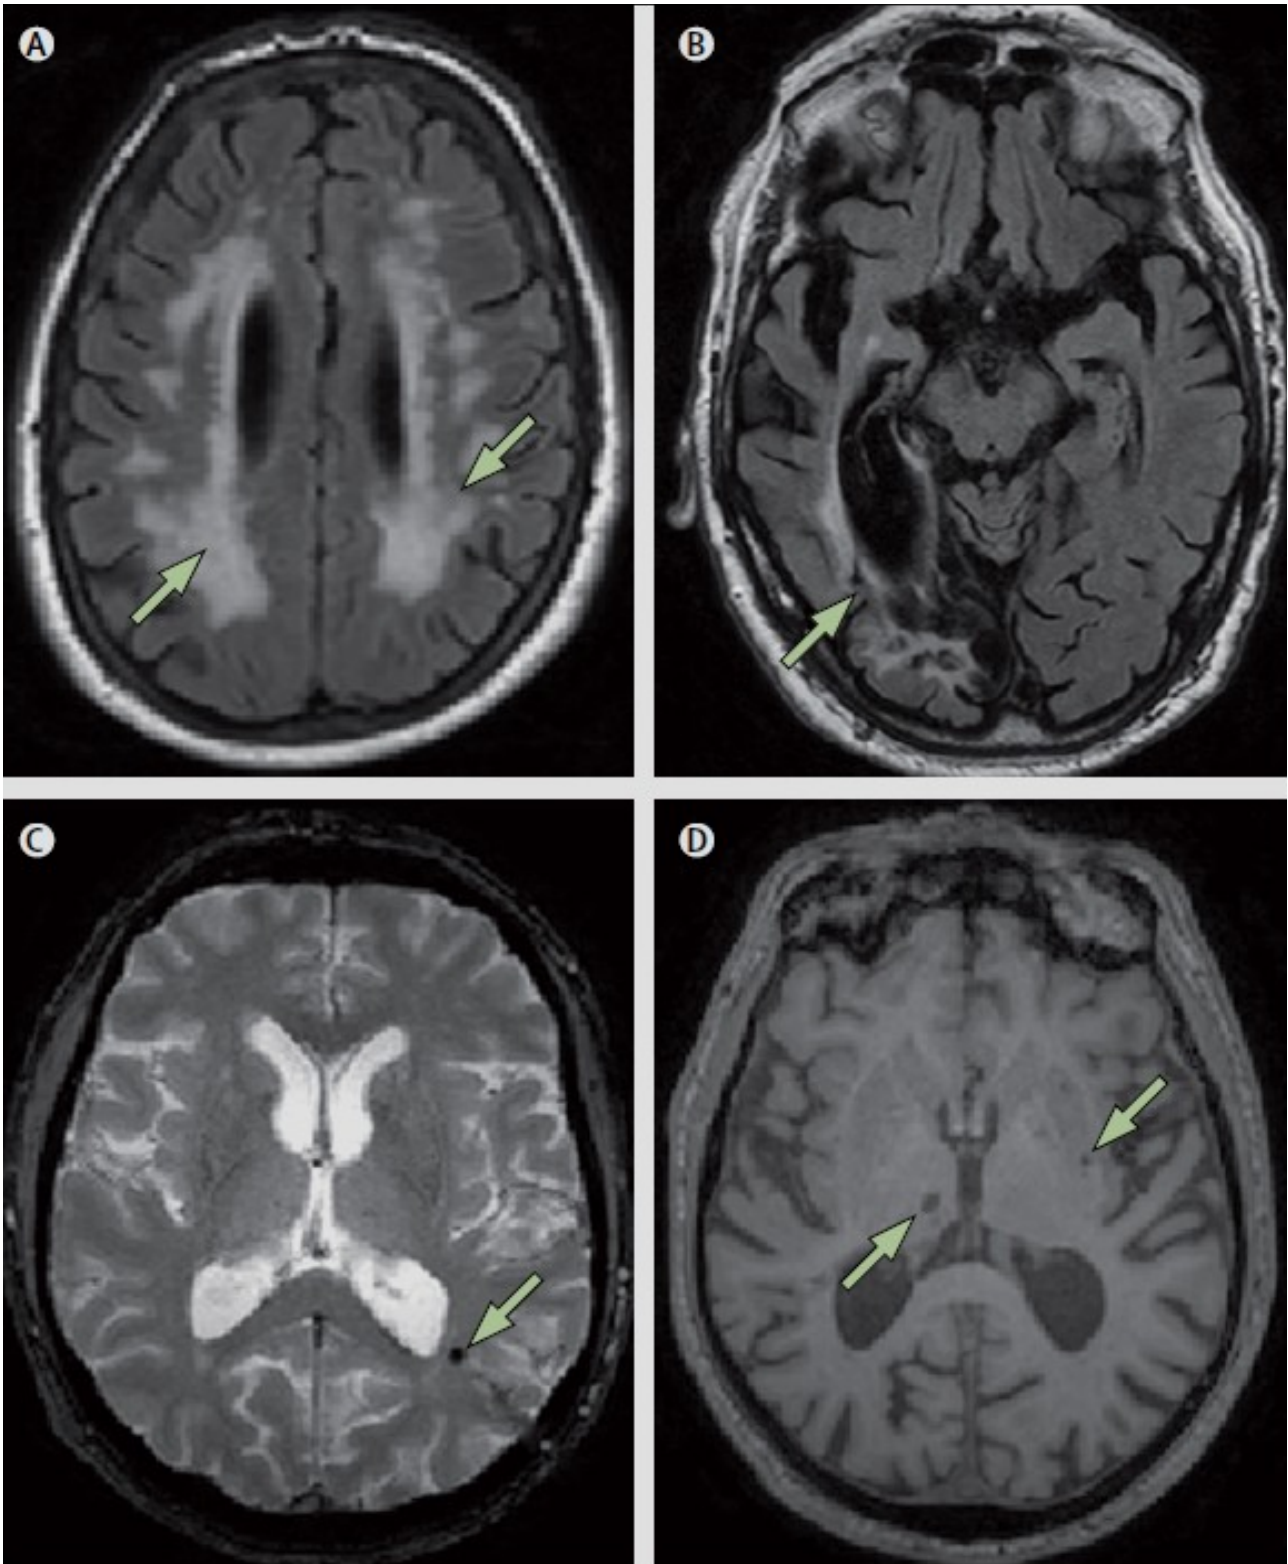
Vascular imaging changes on MRI.⁷²
